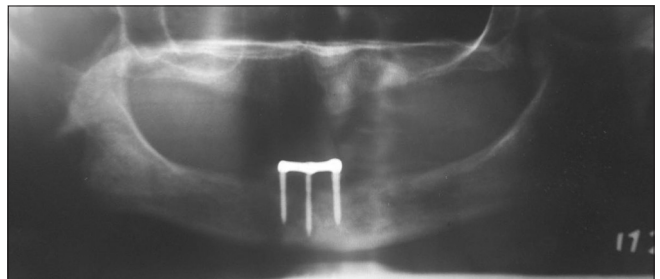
Orthopantomogram showing maintenance of marginal bone level around the splinted mini implants after 3 years of placement
